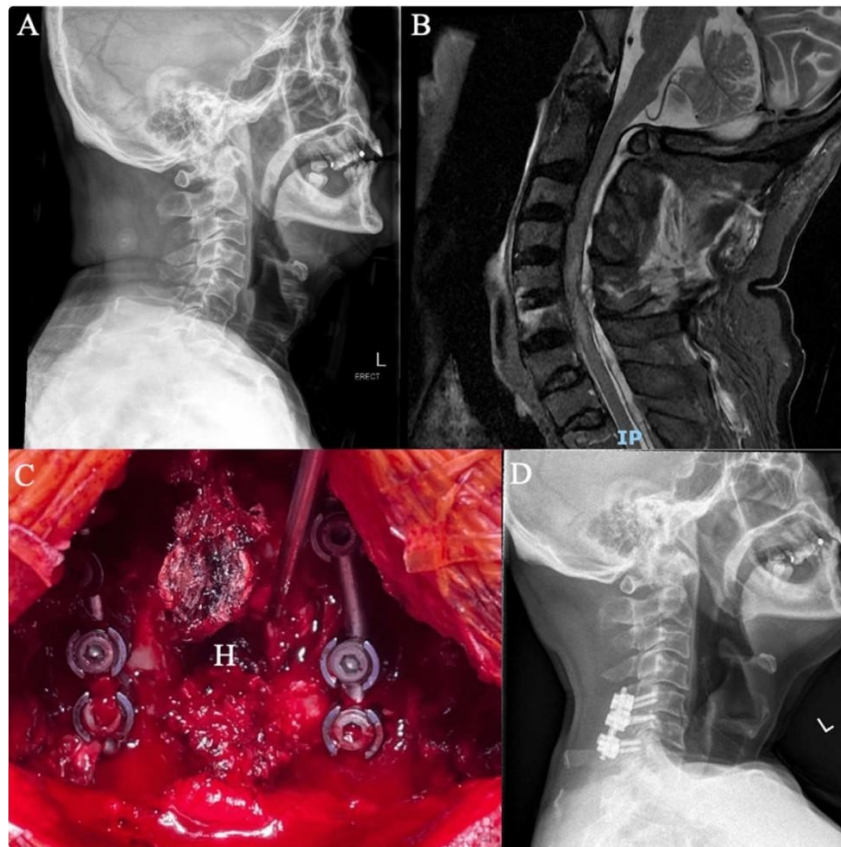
Case no. 2. (A) Lateral cervical X-ray: Minimally displaced vertebral body fractures at C5 and C6, (B) Cervical MRI (MRI-CS): Large epidural hematoma from C1 to T2 with cord edema at C4-C6, (C) Intraoperative photo: Hematoma (labeled "H"), (D) Postoperative lateral cervical X-ray: Stable implants.
